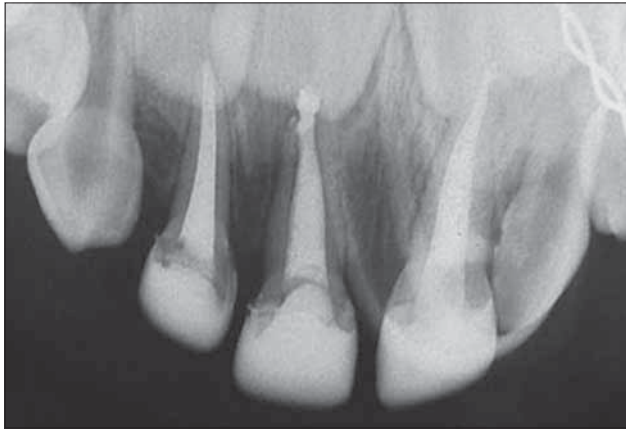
Immediate postoperative radiograph of pulpectomized incisors in a 30-month-old patient. The right central incisor demonstrated overfill of the ZOE paste.
